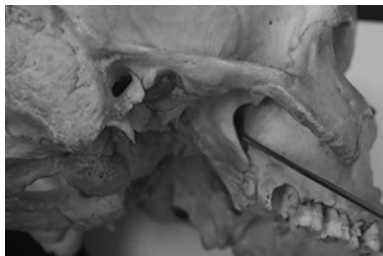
Photograph of a skull with the 14-gauge cannula inserted into the inferior orbital fissure instead of the adjacent foramen ovale. If only a lateral radiograph is used during surgery, it may seem that the cannula is properly positioned at the foramen ovale when it is not.
